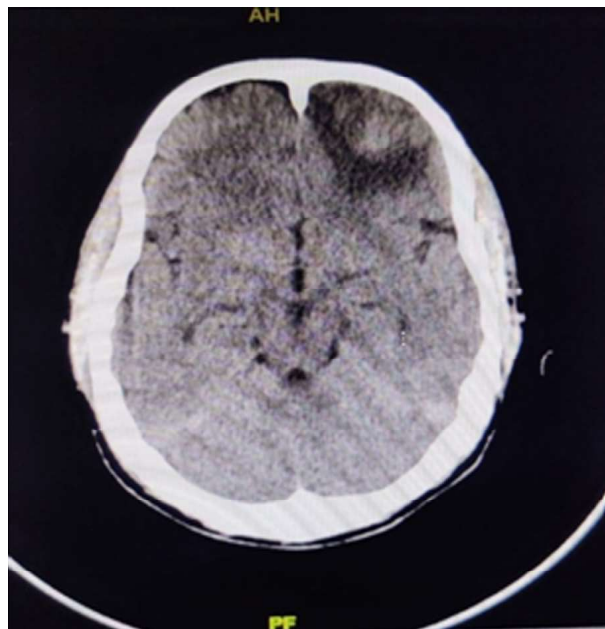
CT brain showing cerebral infarction in left frontal region
